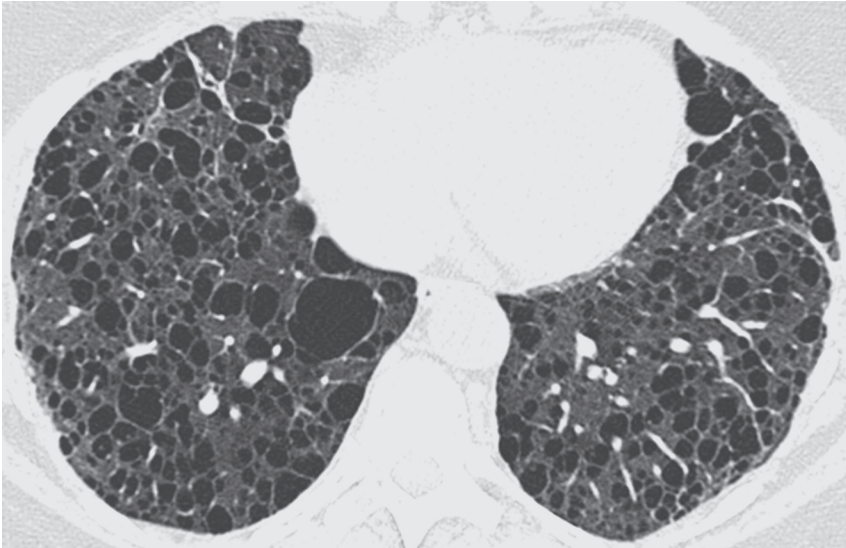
Unenhanced axial CT image of the chest shows numerous bilateral thin-walled cysts, most of which are similar in size. The intervening lung is normal.
